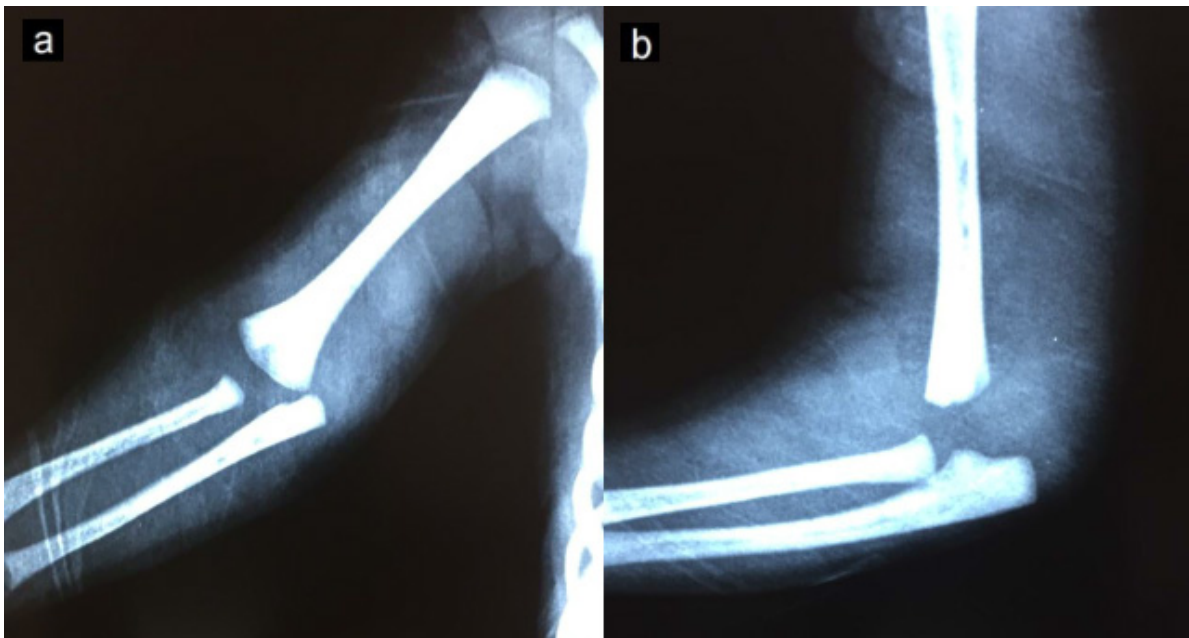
Preoperative right upper limb radiograph, in a five-day-old neonate, presenting a distal humerus Salter-Harris type 1 fracture. Anteroposterior (A) and profile (B) views showing postero-medial elbow deviation
